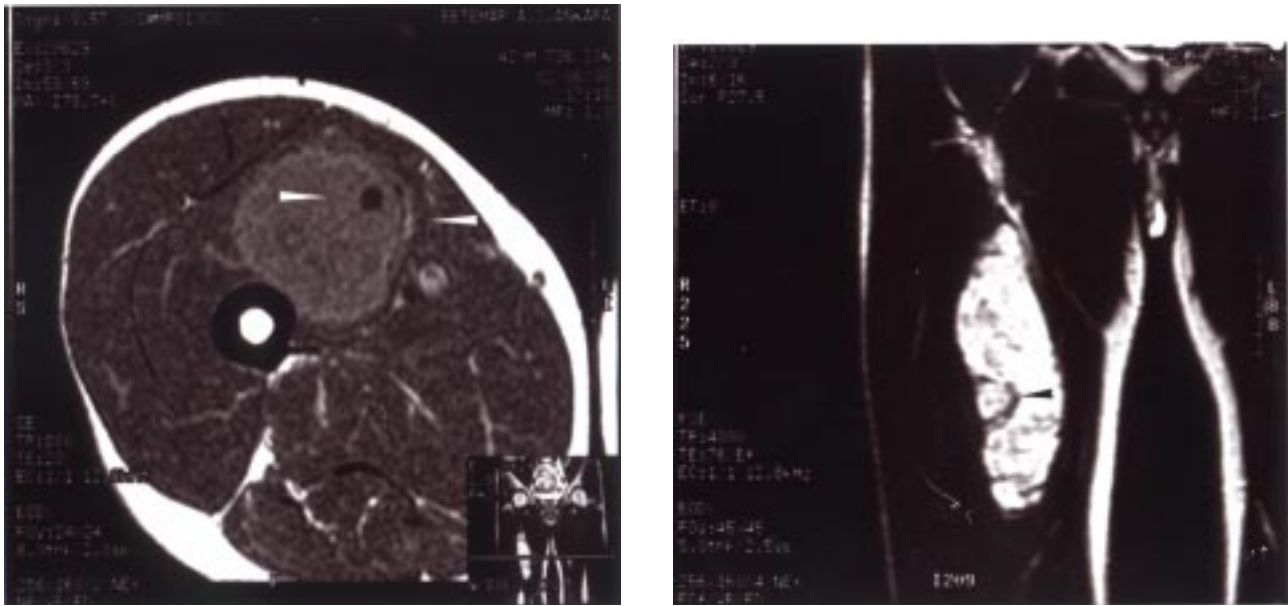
A-B: Axial T1 and coronal T2 weighted MRI scans of the lesion.
